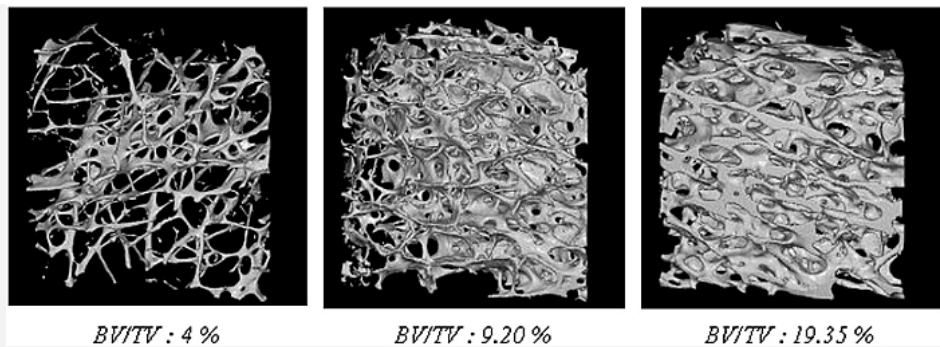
Examples of 3D reconstruction from synchrotron μ -CT experiments. Reproduced from Bone, 42:1193-202, Copyright (2008), with permission from Elsevier.
